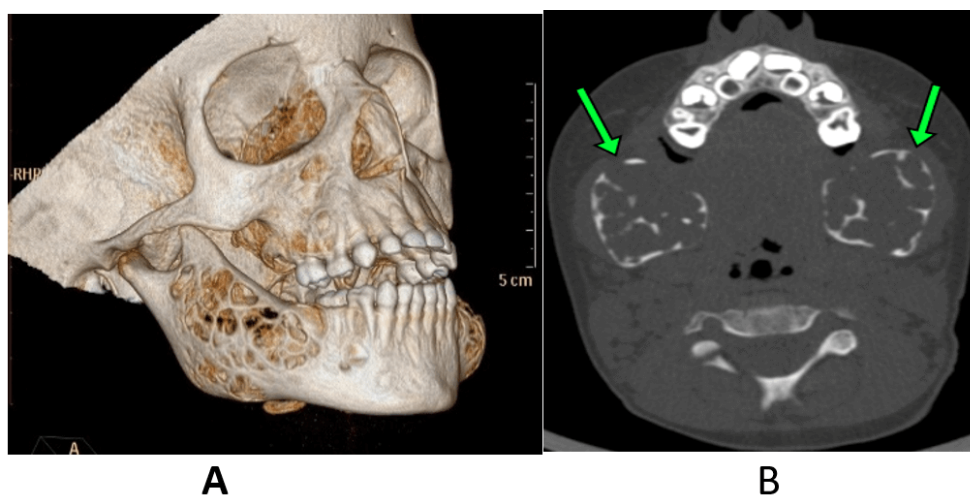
A, 3D reconstruction; B, axial CT scan shows bilateral mandibular bone expansile lytic with internal trabeculations at presentation.
